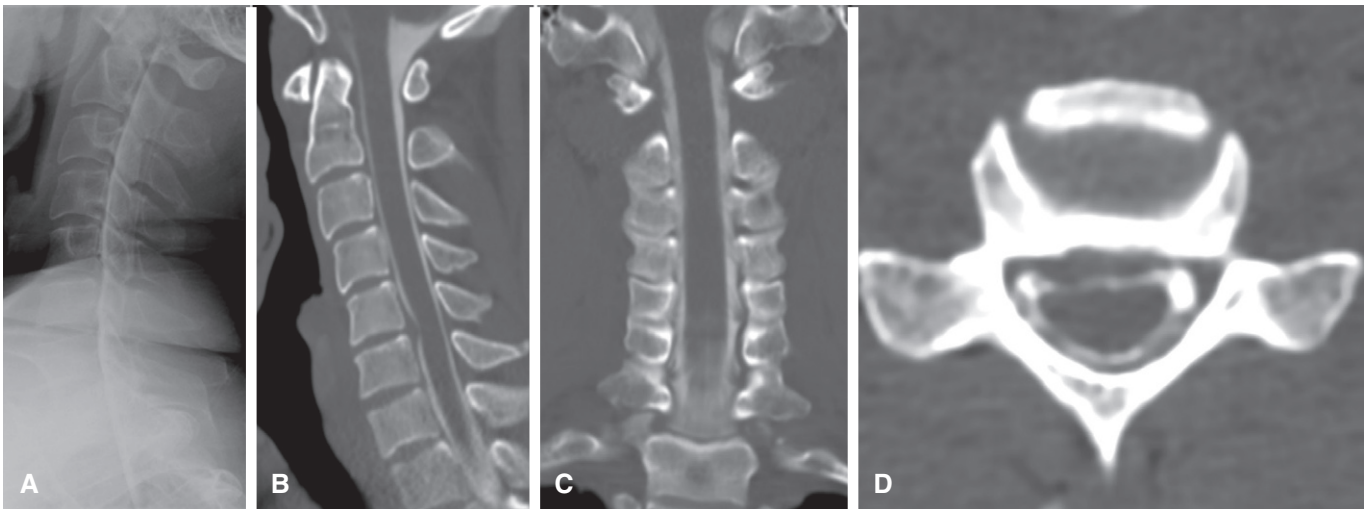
A 38-year-old male shows a right paracentral broad-based disc at C5–6 level causing moderate canal and right neural foraminal stenosis on conventional cervical myelogram lateral view (A), computed tomography myelogram, sagittal (B), coronal (C) and axial (D) reconstructed images.
